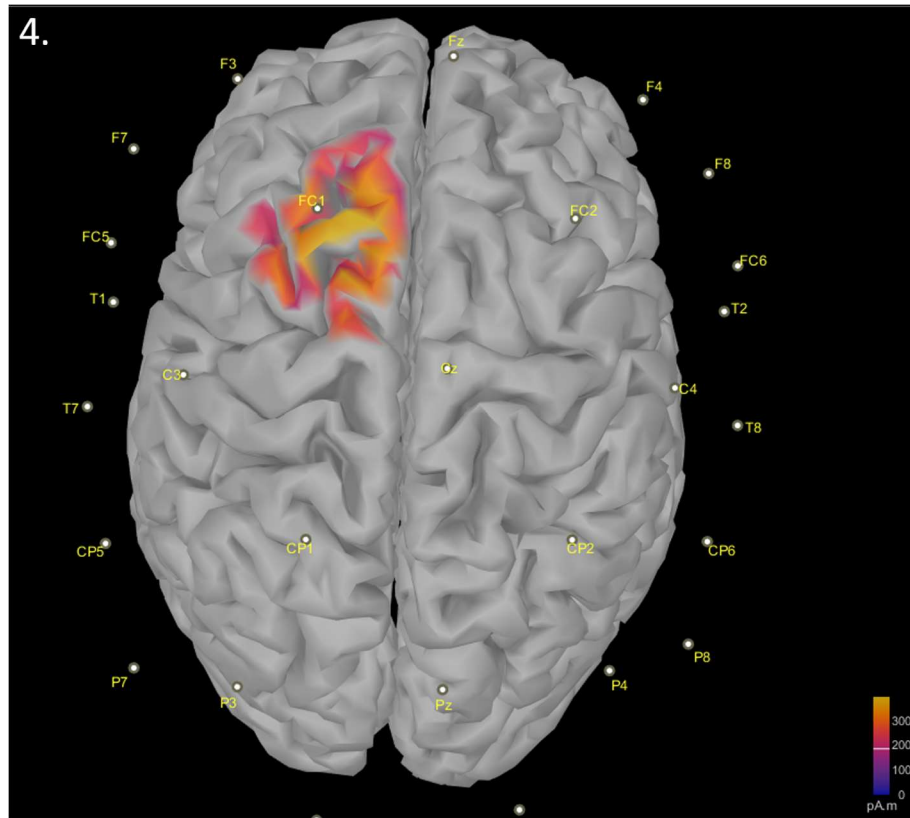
Epileptic activity origin on 3D computer-generated image based on patient's T1 MRI with Brainstorm¹. Red & yellow region indicates neuronal activity above 200pAm, showing epileptic activity origin at FC1 channel as seen in figure 3.A.ii. The axial view of the brain shows the region on the cortex of the left hemisphere (neurological orientation), slightly rostral to the midline. Combining EEG with MRI information is important to line up the electrodes to the precise brain area they measure as EEG signals do not provide enough information about precise origin. MNE can be used for this. This is useful when surgery is required to know which part of the brain to remove.
